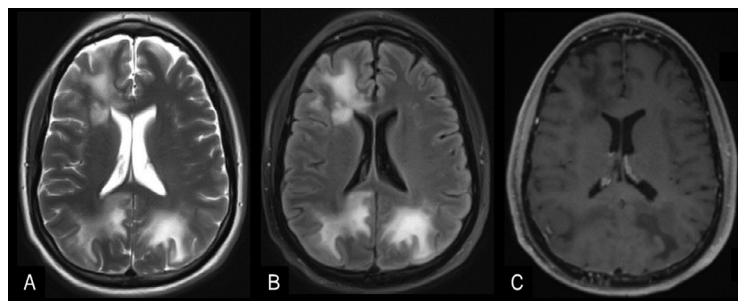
Axial T2 (A) and FLAIR (B) MRI images of the brain showing geographic and confluent T2 and FLAIR hyperintense signal involving the bilateral supratentorial white matter. Axial postcontrast T1 (C) demonstrates no associated enhancement.
